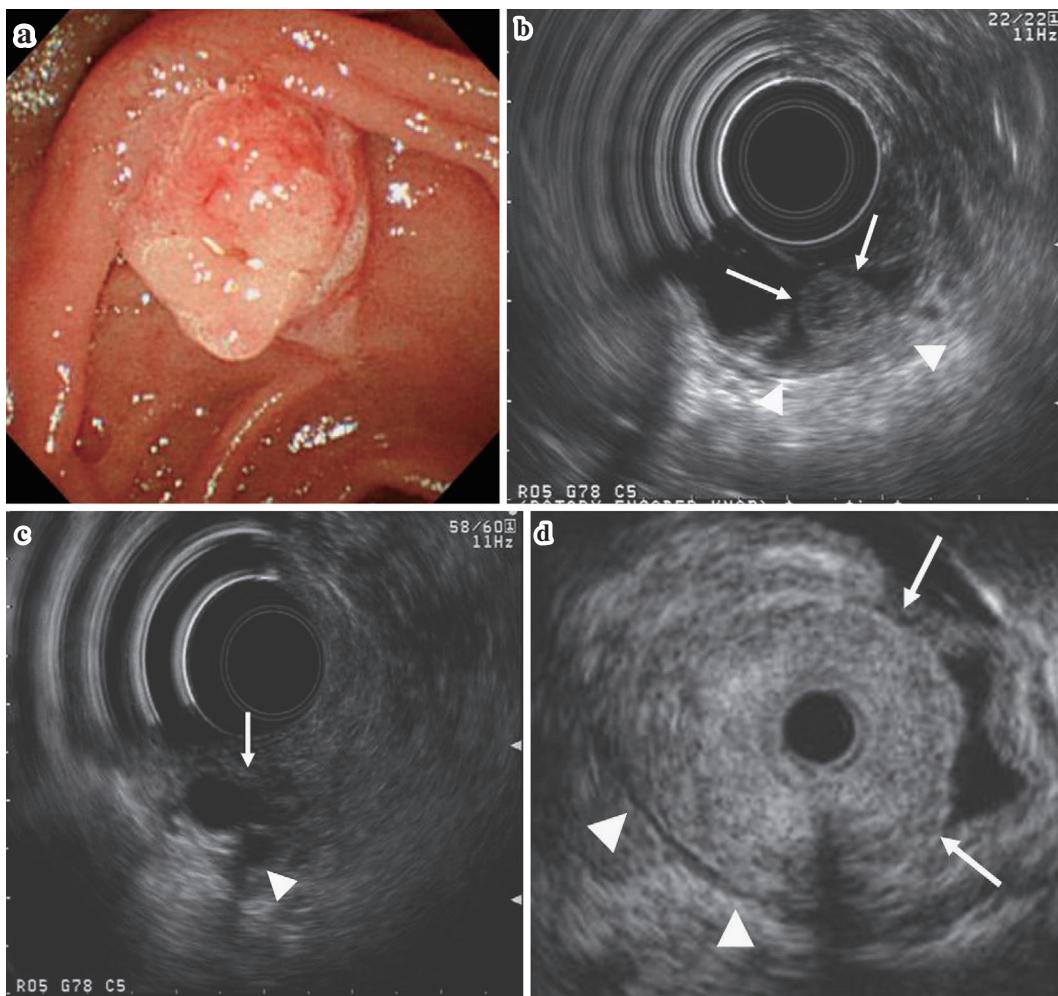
a: Duodenoscopy revealed an exposed-type tumor mass at the ampulla of Vater. b: Endoscopic ultrasonography revealed a hypoechoic mass (arrow) showing no invasion of the duodenal muscularis propria (arrowhead). c: The hypoechoic mass showed no invasion of the bile duct terminal (arrow), and main pancreatic duct terminal (arrowhead). d: Intraductal ultrasonography revealed a hypoechoic mass (arrow) showing no invasion of the duodenal muscularis propria (arrowhead).
